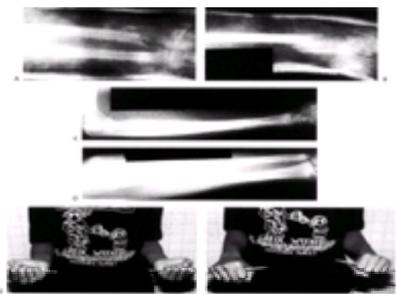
Distal radius and ulna fractures in a 14-year, 6-month-old boy. A and B: Bayonet apposition was accepted in cast. C and D: Eighteen months after injury, radiographs demonstrate satisfactory remodeling. E and F: Range of motion and function are symmetric.
